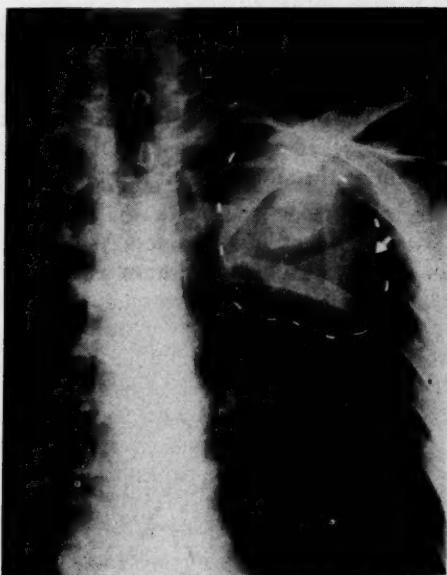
Case 2. Roentgenogram demonstrating tumor mass (dotted outline) in the upper left thorax, with erosion of the fourth rib (note end of rib at arrow).
